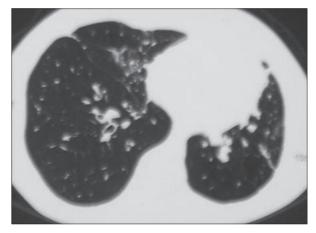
HRCT showed peribronchial thicknesses, bronchiectasis in the localization of medial and lateral segments of right middle lobe
